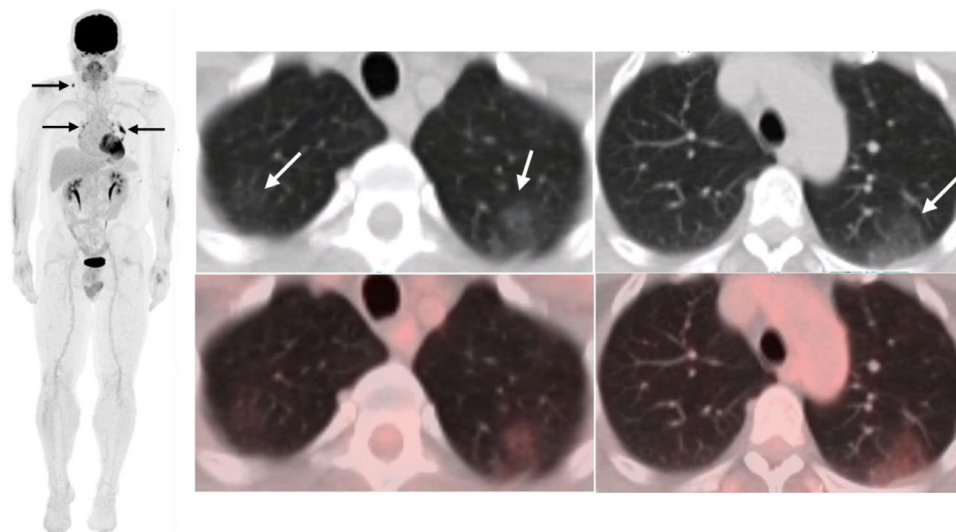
54-year-old male with lacrolentiginous melanoma on nivolumab. MIP image shows metastatic left lower lobe nodule and right scapula lesion with mediastinal lymphadenopathy (black arrows). Axial PET/CT shows bilateral upper lobes lung opacities with mild uptake (white arrows). RT-PCR done resulted negative.
